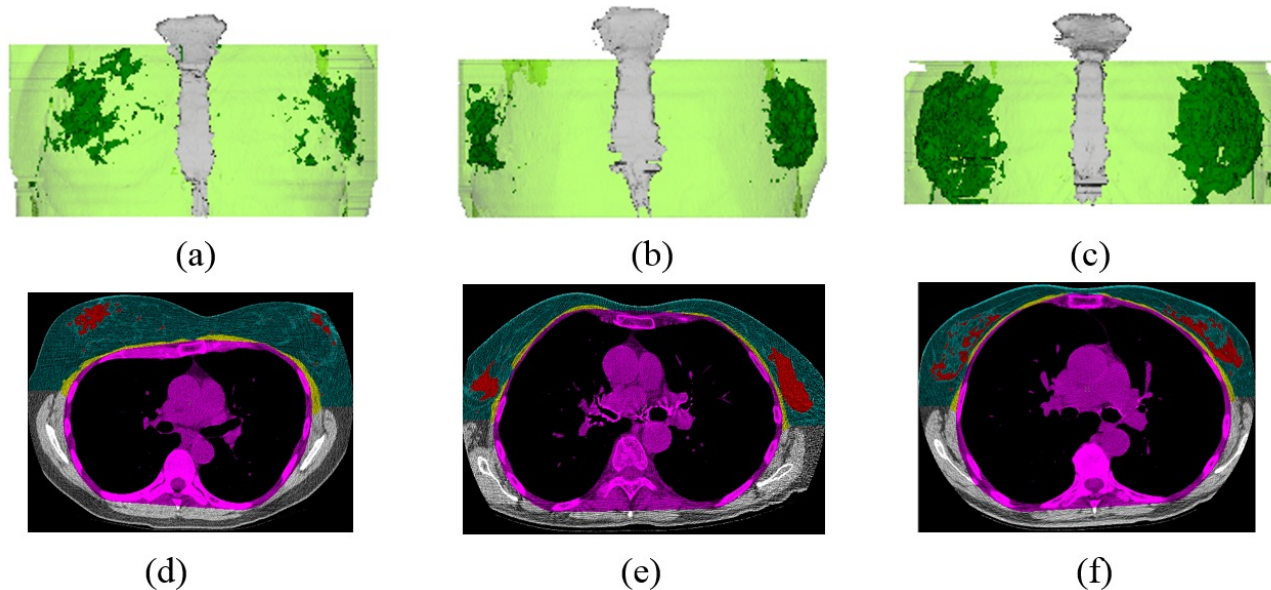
(a-c) 3D coronal visualizations of the whole breast segmentation (in light green) from three different CT scans. The segmentation of sternum (in grey) and the mammary glands (in dark green) are also shown as reference. (d-f) 2D axial visualization of the whole breast segmentation (in blue) for respective scans in the first row. The mammary glands G (in red), the muscles M_A (in yellow), and the thoracic cavity C (in purple) are also shown as reference.
